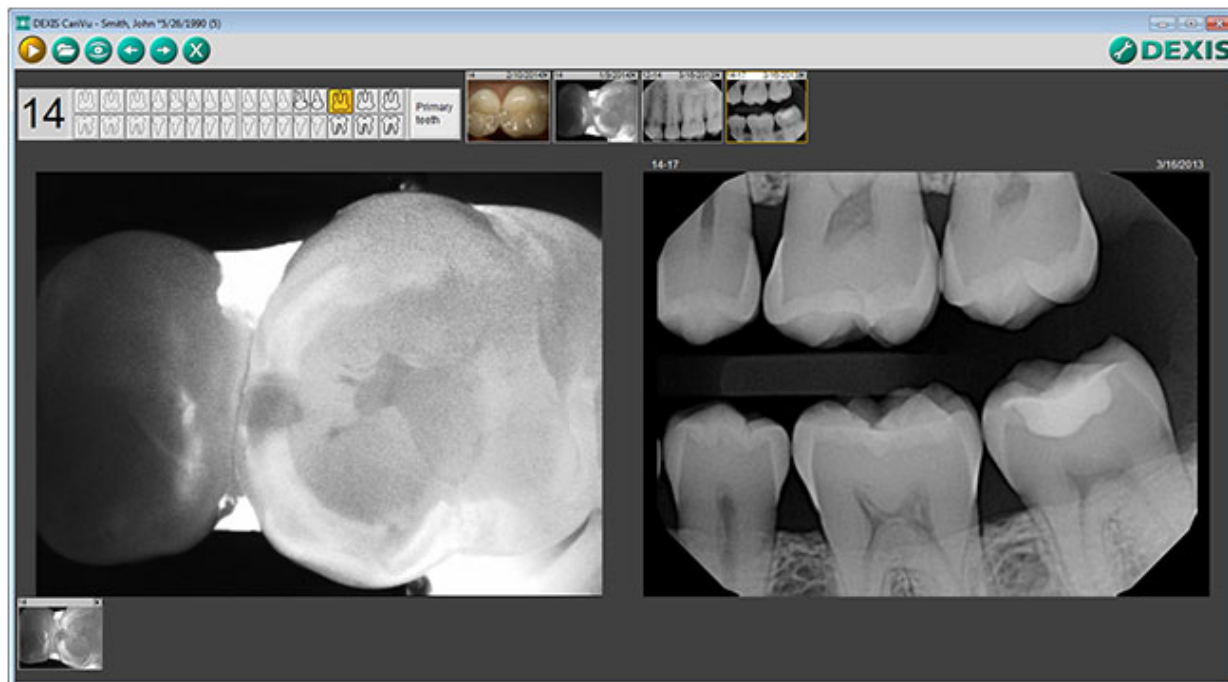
A depiction of a CariVu image (left) alongside a traditional bitewing image (right) of the same tooth surfaces (DEXIS, 2016).
